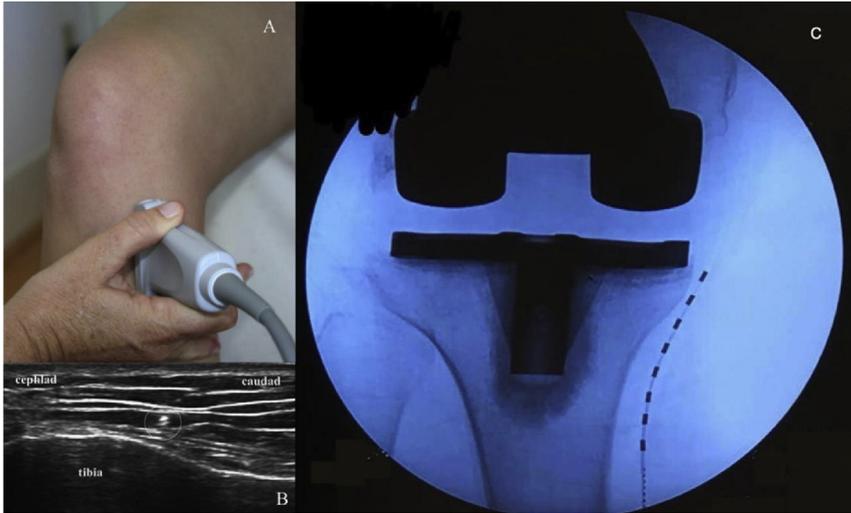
Peripheral nerve stimulator placed through ultrasound for chronic knee pain.
